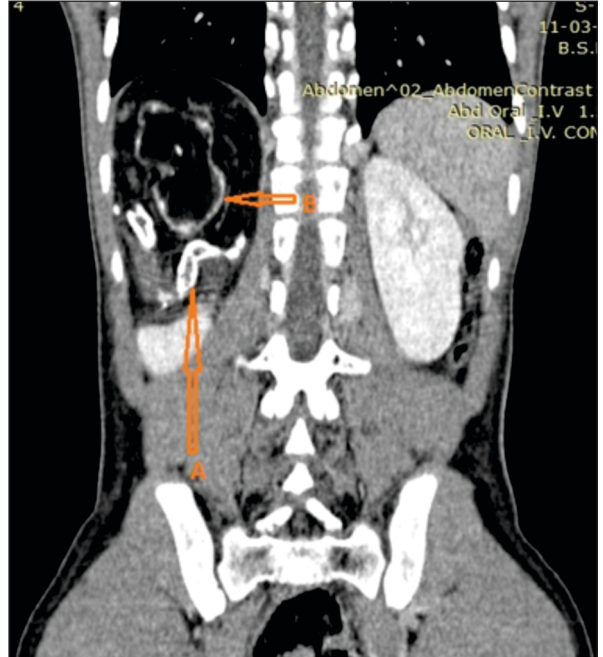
Contrast enhanced computed tomography abdomen coronal shows a large heterogenous mixed density retroperitoneal SOL noted at right hypochondrium with fluid density, calcified, soft tissue and fat components (A) Deformed long bone (B)Deformed calvaria
